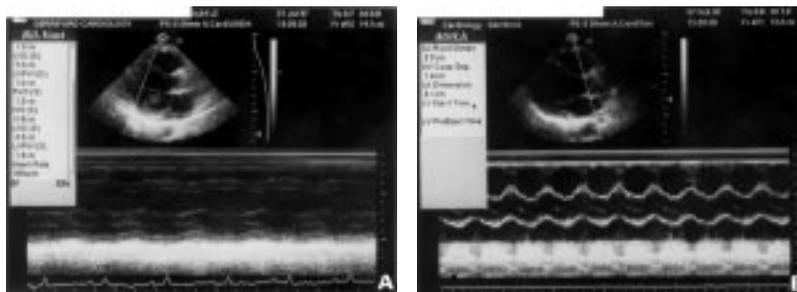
M-Mode echocardiograms taken before (A) and after (B) chemotherapy
